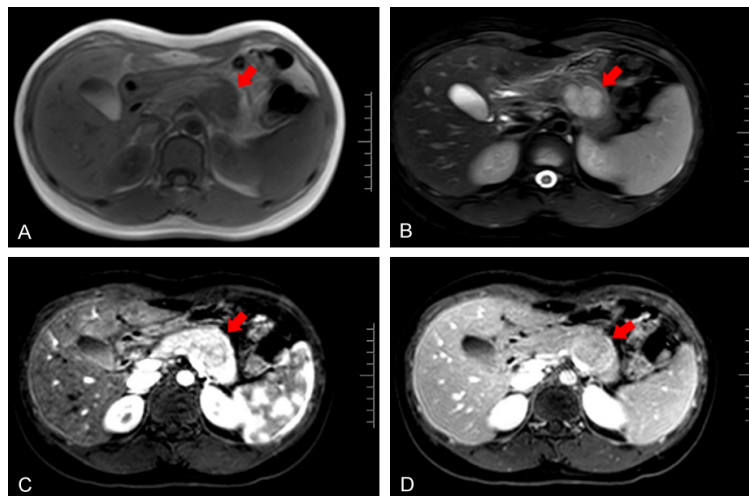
The mass (red arrows) was well-defined, predominantly hypointense on T1-weighted magnetic resonance imaging (MRI) (A), and hyperintense on T2-weighted image (B). Contrast-enhanced dynamic MRI showed a lesion with peripheral and progressive enhancement, but slightly less than the normal pancreatic parenchyma (C, D).
